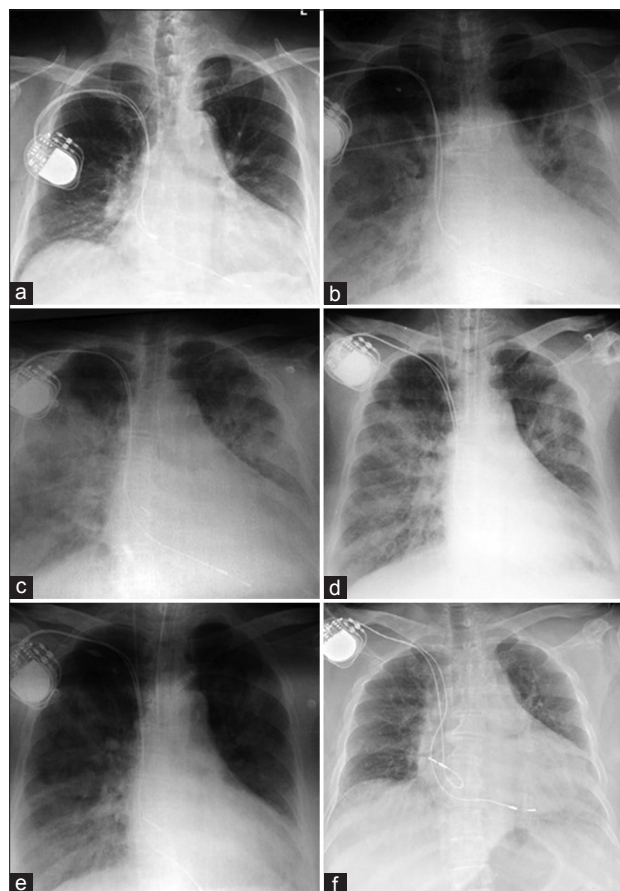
The chest X-ray of the patient: (a) Preoperative; (b) 3 h after operation; (c) 12 h after operation; (d) 24 h after operation; (e) 36 h after operation; and (f) before discharge.
